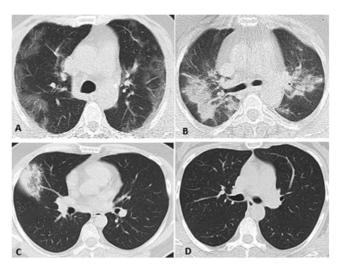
A-D. Axial lung-window chest CT scan shows (A) Typical appearance (bilateral, peripheral, GGO without consolidation), (B) Indeterminate appearance (perihilar consolidation with GGO), (C) Atypical appearance (isolated segmental consolidation without GGO), and (D) Negative for pneumonia (no features to suggest pneumonia).
